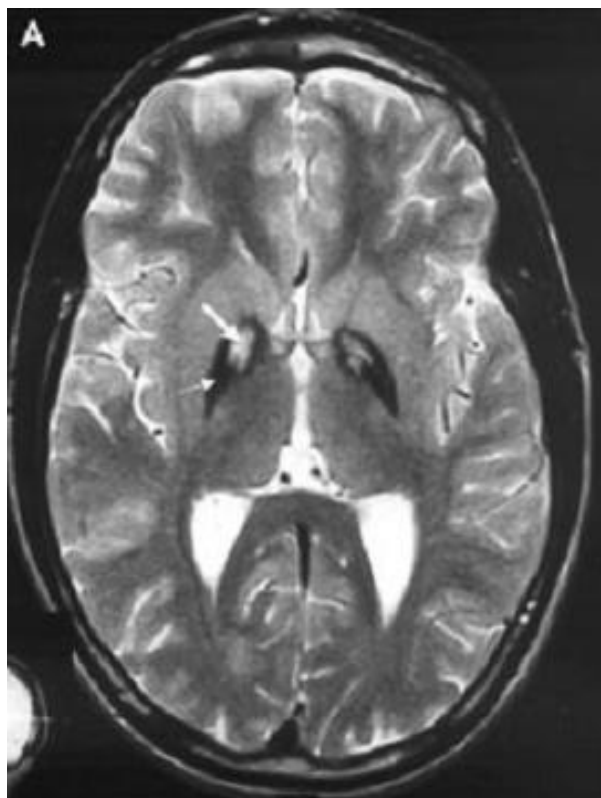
Axial T2-weighted MRI showing an eye-of-the-tiger sign in PKAN
